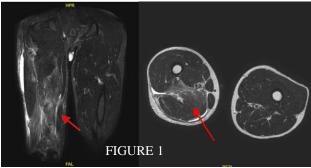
High signal area (arrow) on MRI indicating intramuscular hamstring injury
